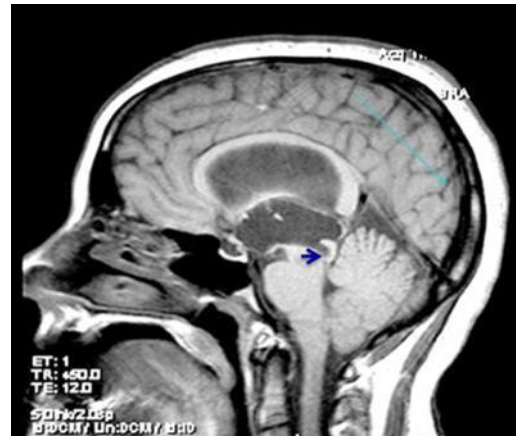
CT image of stenosis of the aqueduct of Sylvius
